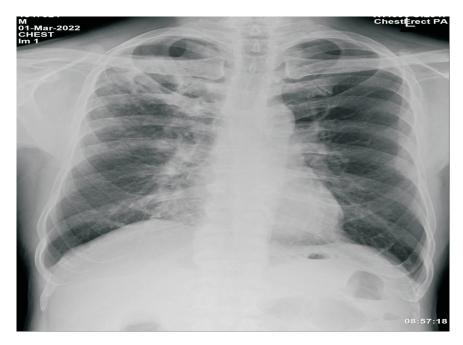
Chest X-Ray: March 1st, 2022
